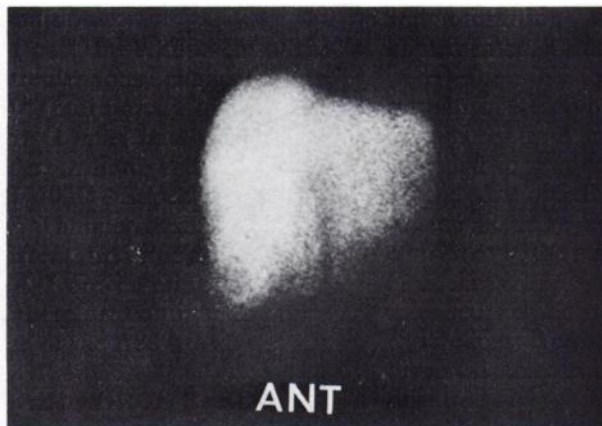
Liver scintigram obtained from Patient 2 shows slight hepatomegaly with mild inhomogeneity.
